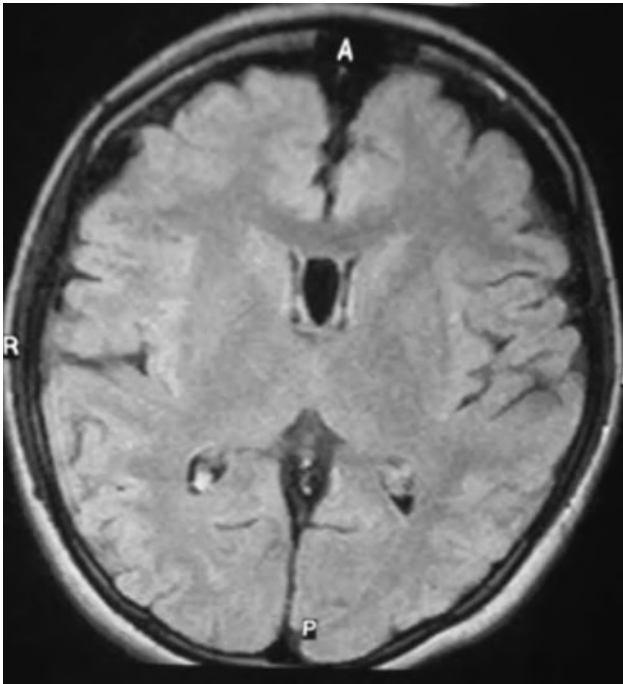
MRI of brain showing diffuse cerebral atrophy which was predominantly cortical.
